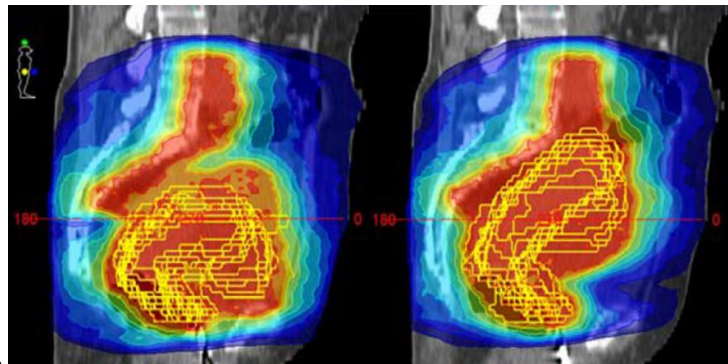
Example of two optimized dose distributions (color wash) for the motion model of the uterus for empty to half-full (left panel) and half-full to full (right panel) bladder. The corresponding uterus positions as measured by the daily CBCT (yellow) for all treatment fractions of one patient are overlaid.
